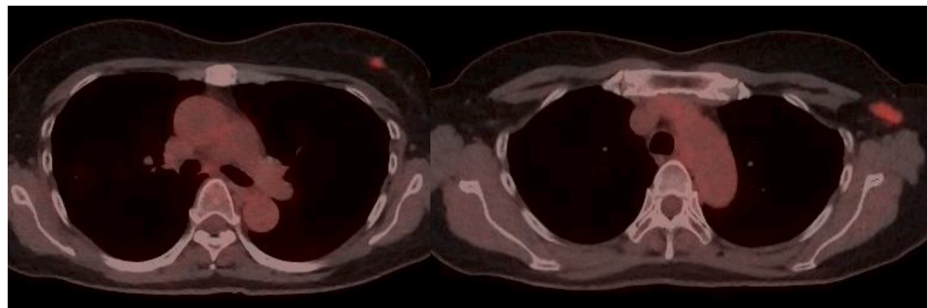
Image of 18 fluorine fluorodeoxyglucose positron emission tomography/computed tomography showing intense fluorodeoxyglucose accumulation in the left breast tumor and left axillary lymph node metastasis.
